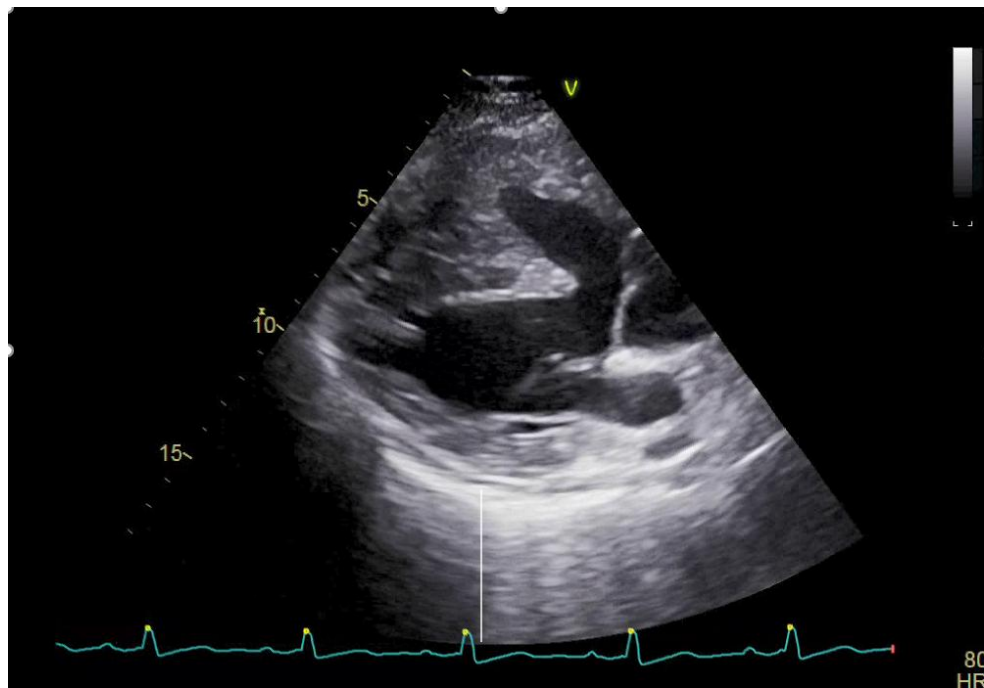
Transthoracic echocardiography showed aortic overriding VSD with d= 25mm, bidirectional shunt, right ventricle hypertrophy
